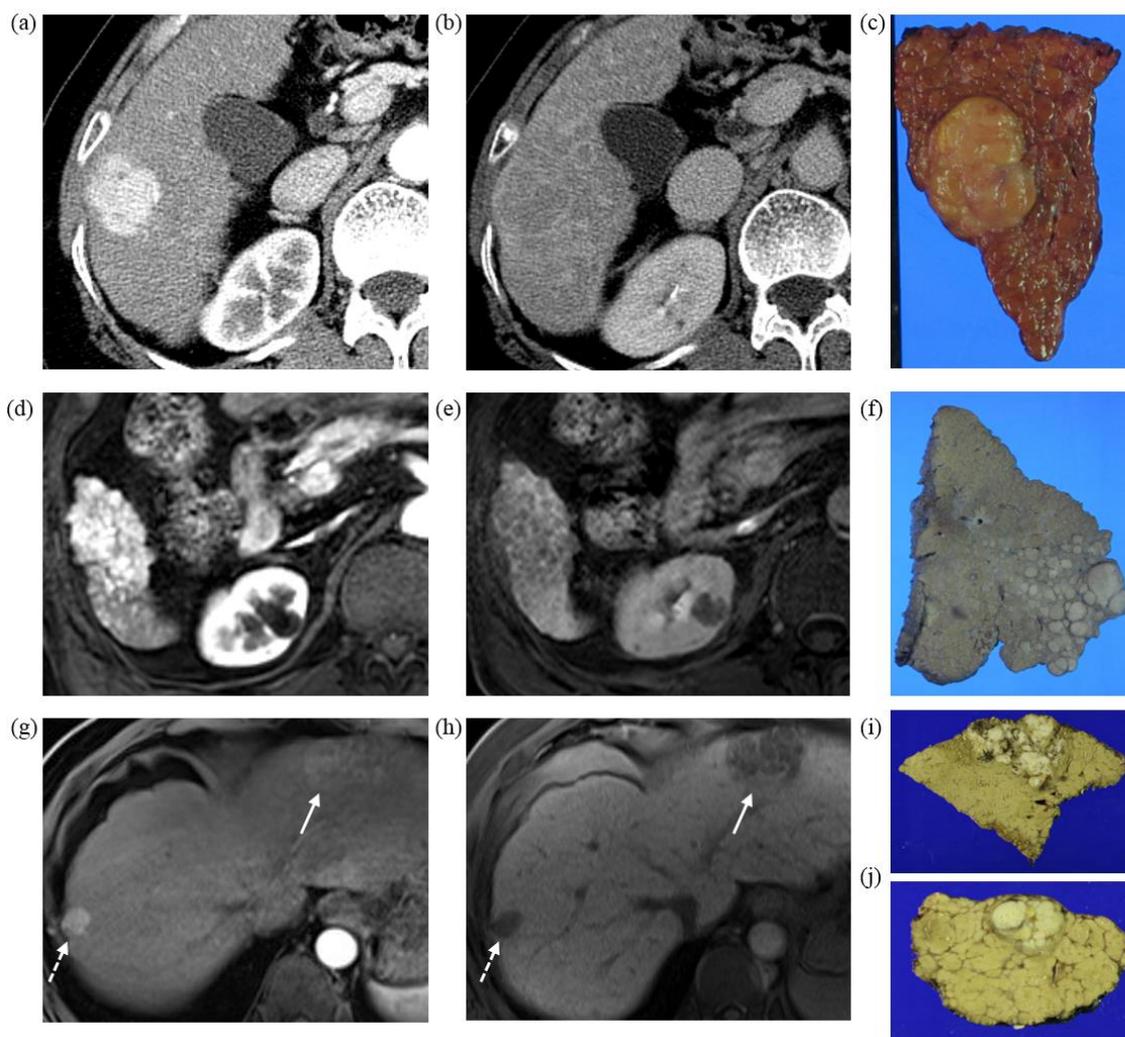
Imaging and gross morphologic subtypes of HCCs. Imaging findings of nodular HCC has typical characteristics of HCC with (a) early arterial hyperenhancement, (b) washout pattern on portal phase in three phase CT and (c) sharp demarcating margin on pathologic finding. Infiltrative HCC staged BCLC A shows (d) tumor with miliary pattern of enhancement in early arterial phase T1-weighted MR image, (e) wash-out pattern at hepatobiliary phase and (f) multiple foci of varying size that fuse to form larger foci without definite margin in pathologic findings. BCLC B staged HCC comprising two HCCs shows (g) inhomogeneous enhancing mass in early arterial phase MR image for larger HCC (solid arrow) and enhancing nodule with discrete margin for another smaller HCC (dotted arrow) and (h) wash-out pattern at hepatobiliary phase for both HCCs. The pathologic findings corresponding to (i) larger HCC shows mass with permeative appearance without distinct margin while (j) smaller HCC has discrete margin.
